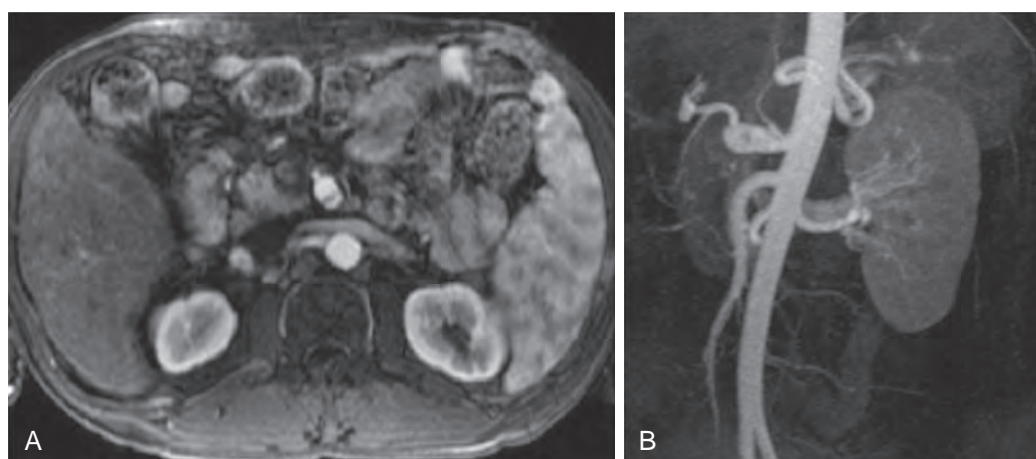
Celiac artery dissection. A. Axial spoiled gradient-echo postgadolinium MRI image demonstrates a dissecting flap within the celiac trunk. B. In a different patient, coronal thick MIP reconstruction from subtraction abdominal MRA with Ablavar demonstrates a celiac artery aneurysm with isolated celiac dissection.
